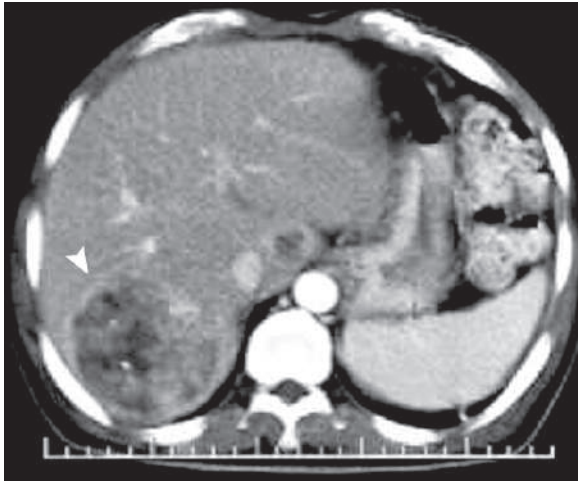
Axial postcontrast abdominal CT shows liver abscess developed in a patient after typhoid septicemia (*arrowhead*)
